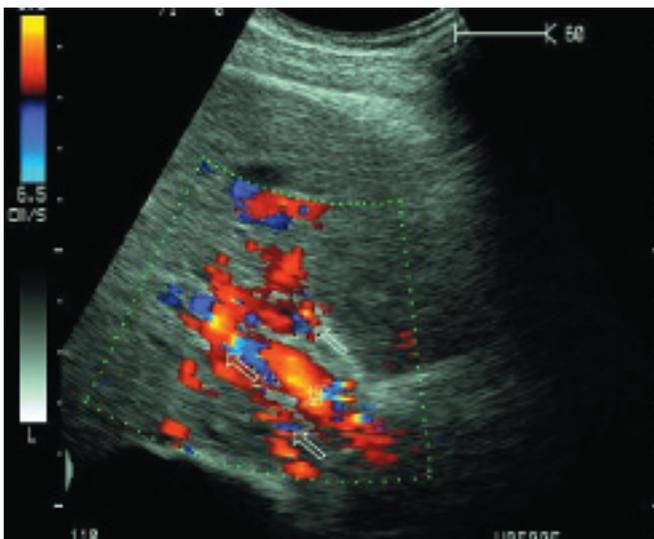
Color Doppler ultrasonography: portal cavernoma.
